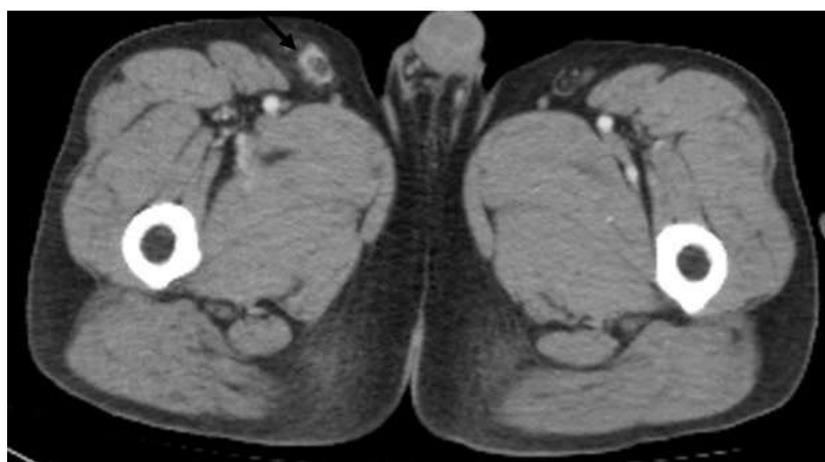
Right inguinal lymphadenitis on CT scan.
